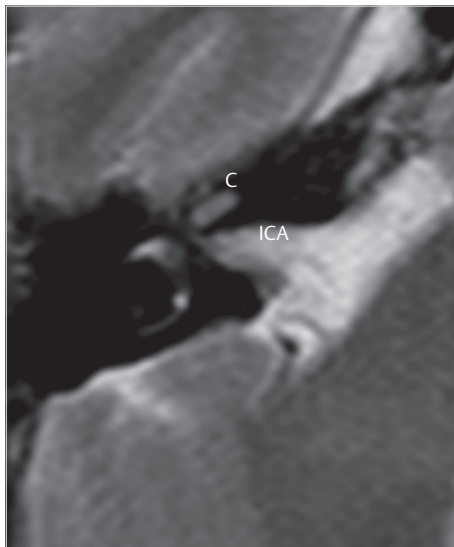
The T2-weighted image MRI shows no pathology in the superior part of the temporal bone including the internal auditory canal (a). Petrous apex lesion located medially to the labyrinth starts to appear one slice inferiorly to it (b). Semicircular canals are identified in this slice. C, cochlea; Ch, cholesteatoma; ICA, internal carotid artery; LSC, lateral semicircular canal; PSC, posterior semicircular canal.
